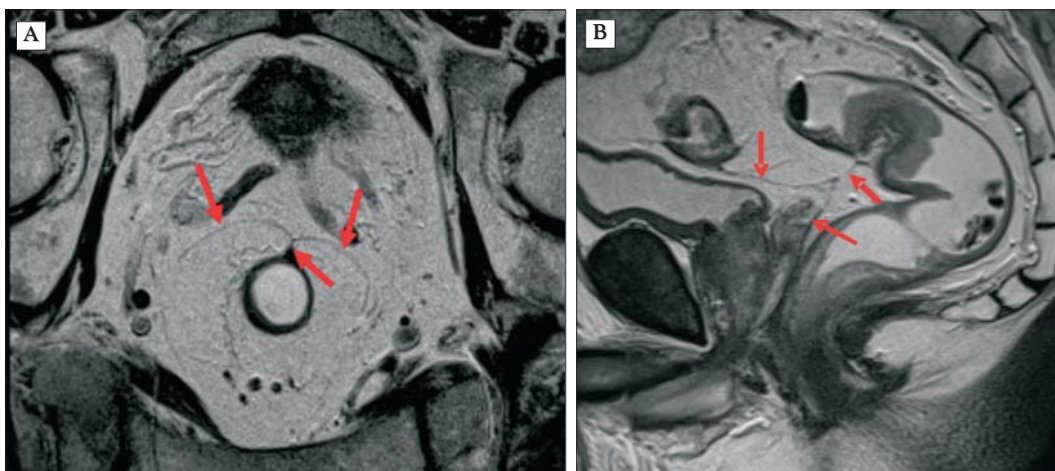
T2 MRI images (A) axial and (B) sagittal showing the peritoneal reflection (arrow). (A) one can observe in the axial plane the typical morphology "seagull sign" and in the sagittal plane (B) the fine linear structure above the bladder and prostate which extends to the rectum in a V or Y shape.
